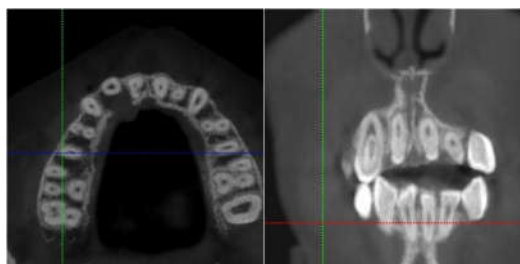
Axial & Coronal Sections of CBCT
